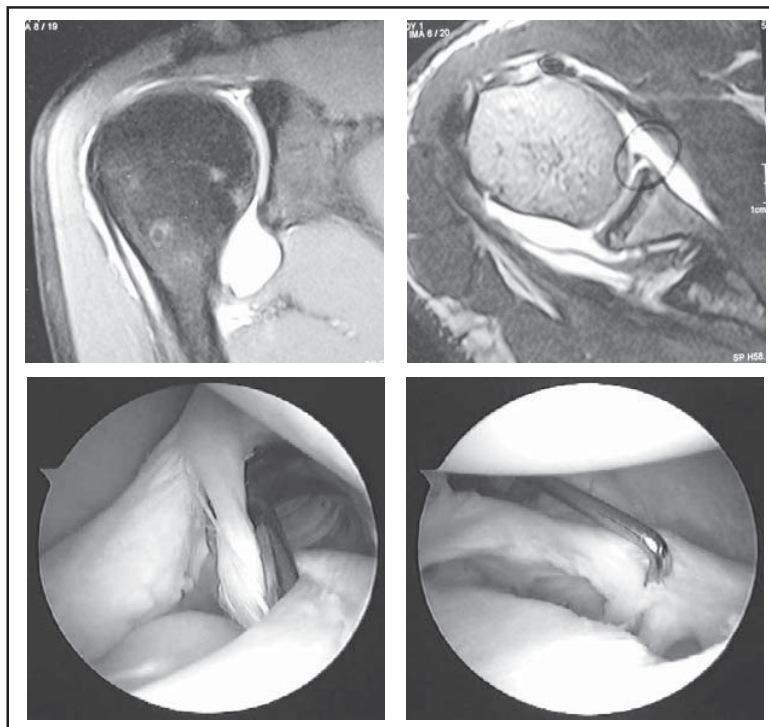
Type V SLAP tear : MRI-arthrogram and arthroscopic images (patient in lateral position)
